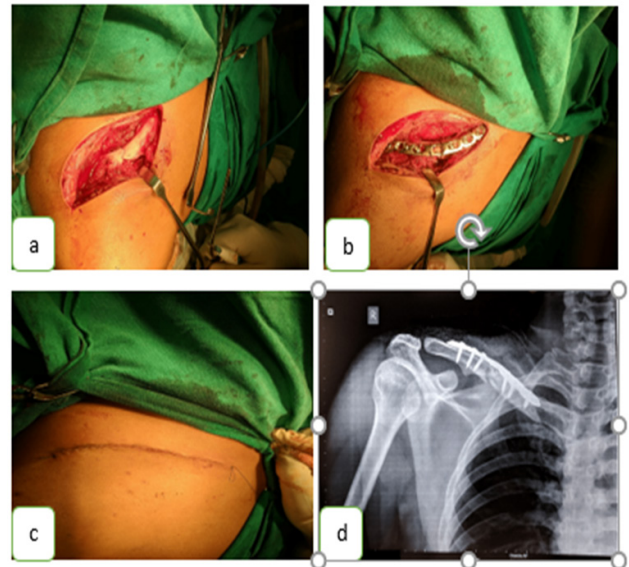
Intraoperative pictures showing: a) clavicle fracture reduction; b) anatomical pre-counter plate application; c) skin after final closure; d) post-operative X-ray
